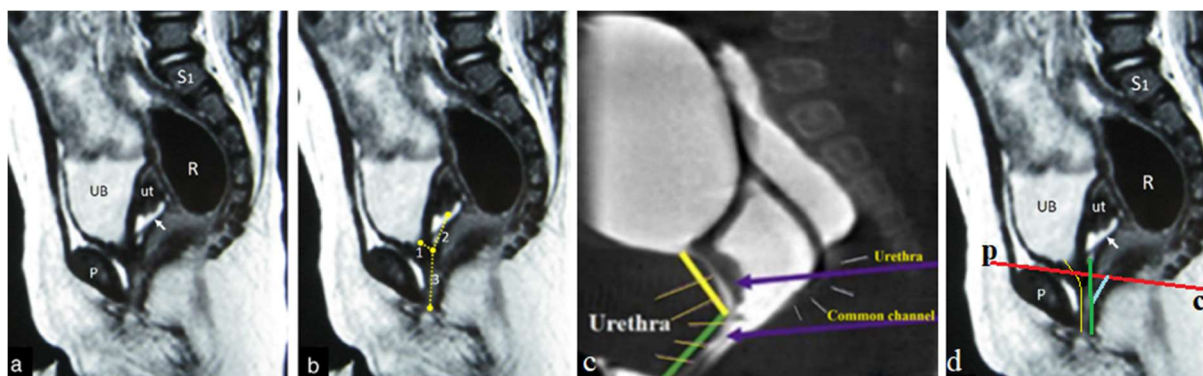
(a,b). From AbouZeid and Mohammad [4]. Signature of the authors of the article: “Demonstration of the abnormal pelvic MRI anatomy in a case of cloaca (22-month-old). (a) Note: the vagina is distended with fluid that appears hyperintense (white arrow) like the urinary bladder. The lower end of the distended vagina marks for the level of urogenital confluence. (b) The urethral length (1) is measured as the distance between the bladder neck and the urogenital confluence; the vaginal length (2) is measured as the distance between the uterine cervix and the urogenital confluence; and the common channel (3) is measured as the distance between the urogenital confluence and the vestibule (just below and behind the lower end of pubic symphysis”. (c). Study from Wood et al [5]. The purple arrows are drawn by the authors of this article. Where “common channel” is indicated, two channels are visible, separated by a gray strip, which represents the walls of the urethra and of the narrow part of the vagina. As in normal, the urethra approaches the vagina and continues its course to the vulva next to the vagina. I marked it with yellow lines. Behind the vagina, a well-contrasted rectum is visible, ending at the level of the PRM (pubococcygeal line). Below it, a poorly contrasted closed anal canal (white lines) is visible. (d). My interpretation of Figure 1.a. The urethra, as in normal, approaches the vagina and continues to be located next to it, as in figure (c). Below the pubococcygeal line is the anal canal (blue), which enters the vagina.
